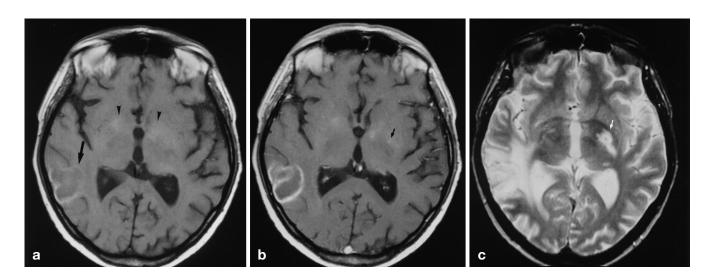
a Axial T1-weighted image reveals a low-signal temporal lesion with an incomplete high-signal ring suggesting a necrotic infectious lesion (*large arrow*). Bilateral foci of high signal in the basal ganglia (*arrowheads*) were thought to be due to calcium or manganese. b There is moderate ring enhancement of the right temporal lesion and only faint enhancement of a left basal ganglion lesion (*small arrow*). c Perifocal oedema is better seen on T2 weighting (*white arrow*). This helped to distinguish between metabolic and infectious basal ganglion changes
